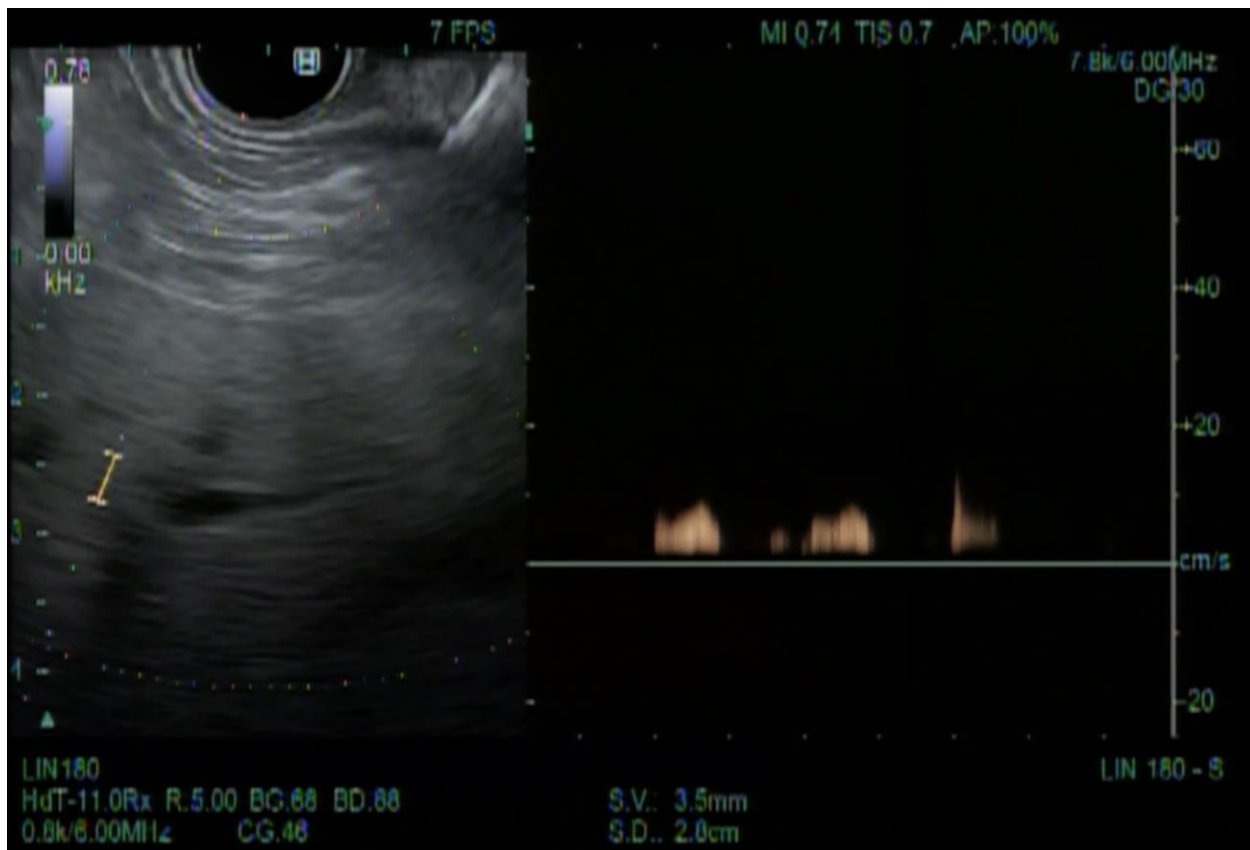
EUS doppler flow signals of portal vein (PV) demonstrating typical monophasic waveform
